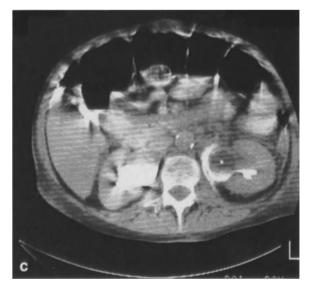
a A CT scan demonstrates extravasation from a dehiscence at the ureteropelvic junction and puddling of contrast medium medial to the kidney. b A CT scan demonstrates a ureterobilial fistula on the left side (*arrows*). c Extravasation in the peripelvic space is appreciated on a post-enhancement CT scan. The pelvis itself is devoid of opacified urine. This appearance is characteristic for opacification via peripelvic lymphatics in patients with obstruction of the ureter
